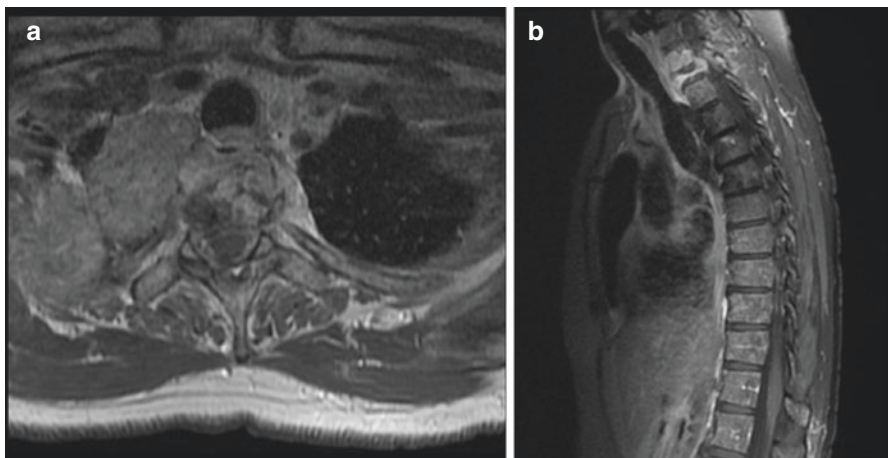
(a) T1-weighted axial MRI with contrast showing tumor-invaded T2 with significant extension to the right intrathoracic cavity and compression of the anterior spinal cord. (b) T1-weighted sagittal MRI with contrast showing a tumor invaded collapsed T2 and anterior epidural as well as anterior spinal extension
